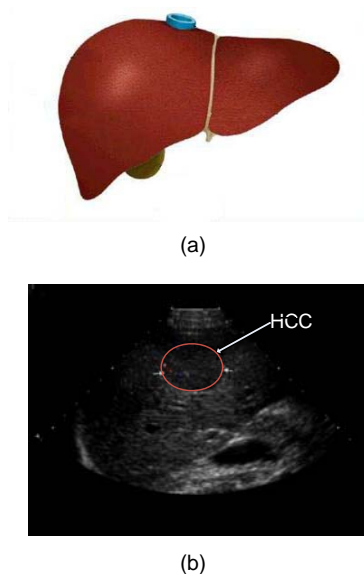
Liver cancer (a) and the ultrasound image of HCC (b)
